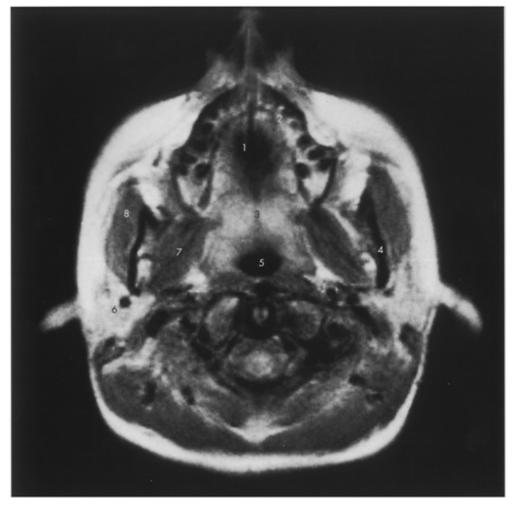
Axial MRI scan of the head at the level of the palate.
